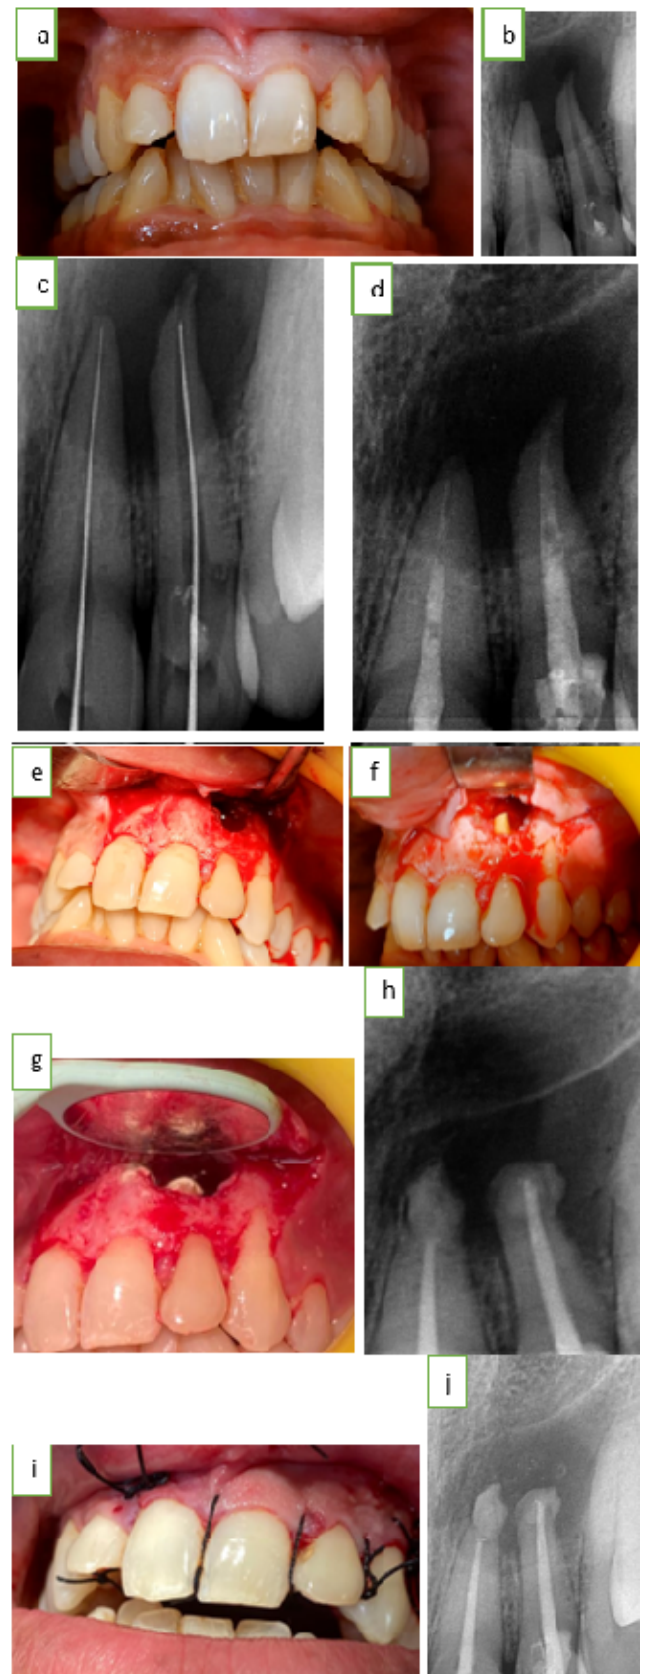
a: Pre-operative image; b: Preoperative radiograph; c: Working length determination; d: Intracanal medicament; e: Full thickness mucoperiosteal flap raised; f: Root end resection; g: Retrograde mta filling image; h: Retrograde mta filling radiograph; i: Sutures placed; J: 6 month follow up.
